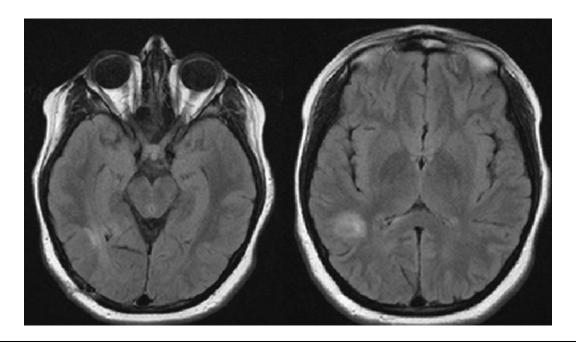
Magnetic resonance imaging 3 months after initial admission. Fluid-attenuated inversion recovery sequence with lessening of the high signal intensity compared with admission scans.
